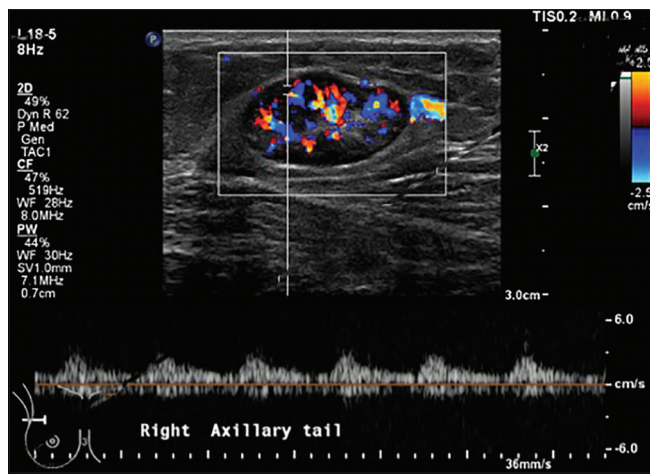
A 61-year-old female who presented with right breast pain and signs of infection. Biopsy proven inflammatory/reactive lymph node (LN). The vascularity is more central than peripheral, thin echogenic capsule is preserved. Pulsed Doppler shows rounded systolic peak with a relative preserved diastolic flow and the Resistive index is not high.
